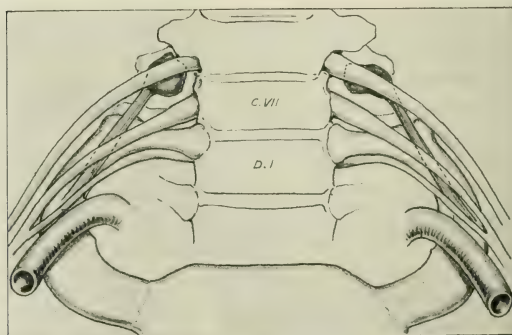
is an example of Type 1, which radiographically was deemed to have no cervical rib. The report was "well marked transverse processes." This patient remains well eleven years after the bilateral operation.
